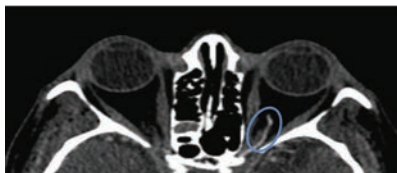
CT angiogram reveals a stenotic right ophthalmic artery (top, red oval) compared to the unaffected left ophthalmic artery (bottom, blue oval).
